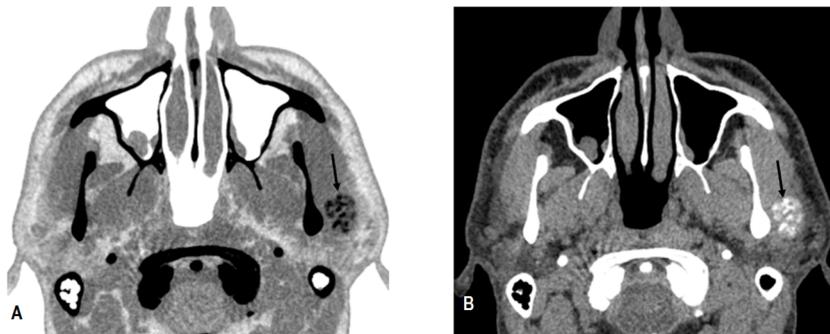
(A/B) Computed tomography in axial view. The lesion seemed internally mixed lateral to the left condylar process and exhibited a discretely hypodense halo (arrow).
